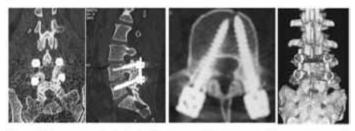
CT scan sections showing Lenke B fusion mass with local bone only. The arrow in the coronal section points to the unilateral small fusion mass.
